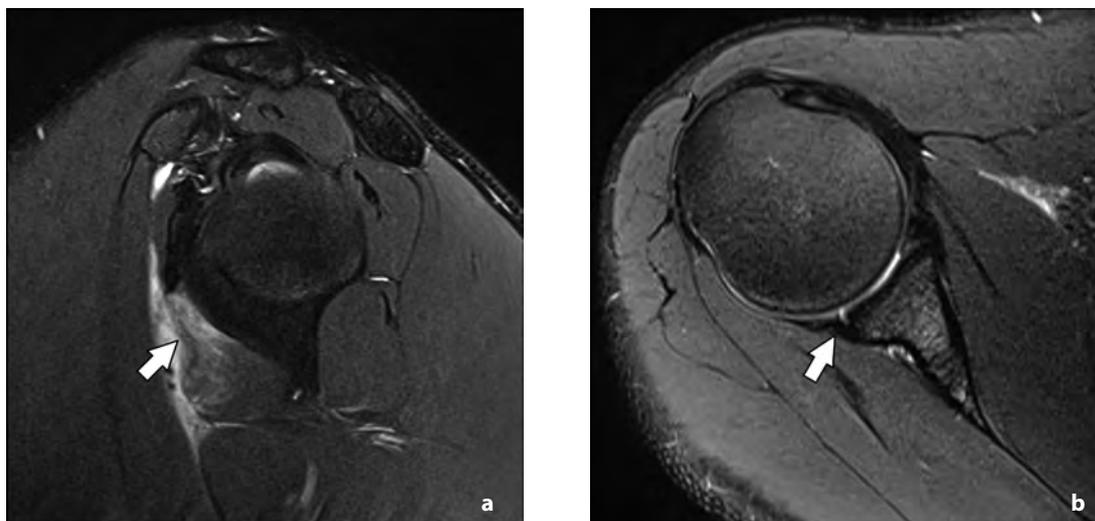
22-year-old, right hand dominant, professional baseball pitcher with shoulder aching following throwing: (a) Sagittal oblique T2-weighted turbo spin echo (TSE) fat-suppressed (FS) MR image of the right shoulder shows a focal grade 2 muscle strain of the inferior subscapularis muscle at the musculotendinous junction (arrow) and additional fascial edema extending toward the axilla. Note high signal intensity in the affected region, (b) Axial T2-weighted TSE FS MR image of the same shoulder shows a small focal posterior labral partial detachment (arrow) without significant bone marrow or soft tissue edema around the labral tear, and with preservation of the adjacent articular cartilage.
